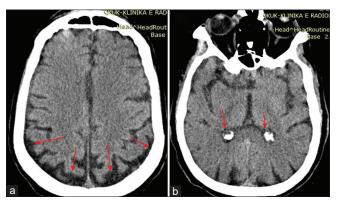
Head computed tomography images of a 64-year-old man with asymptomatic symptom for coronavirus disease 2019. (a) Axial showing subarachnoid space dilated associated with cortical atrophy (Red arrows). (b) Choroid plexus calcification in the lateral ventricles (Red arrows).
